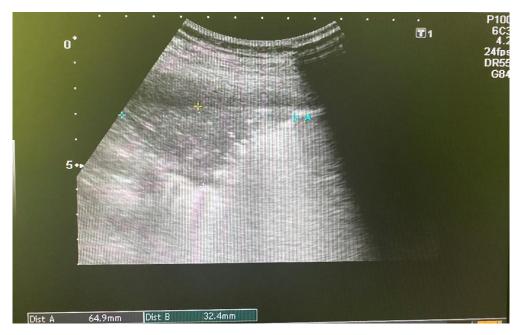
Sonogram of pulmonary consolidation in a 36-year-old patient with pneumonia caused by COVID-19
